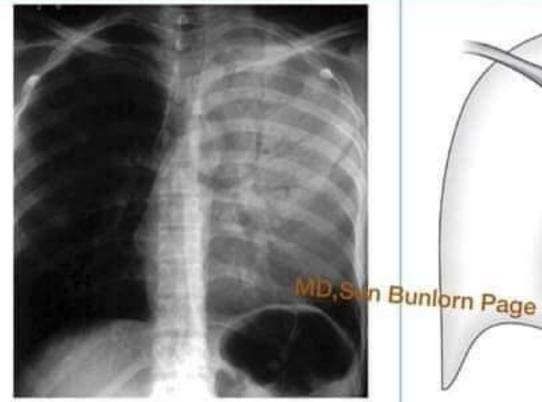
Chest X-ray showing massive pleural effusion
